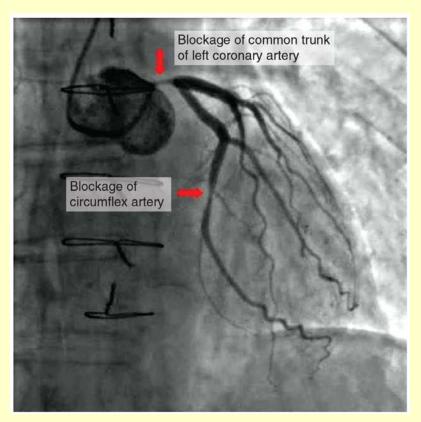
Atherosclerotic Coronary Arteries In this coronary angiogram (X-ray), the dye makes visible two occluded coronary arteries. Such blockages can lead to decreased blood flow (ischemia) and insufficient oxygen (hypoxia) delivered to the cardiac tissues. If uncorrected, this can lead to cardiac muscle death (myocardial infarction).
